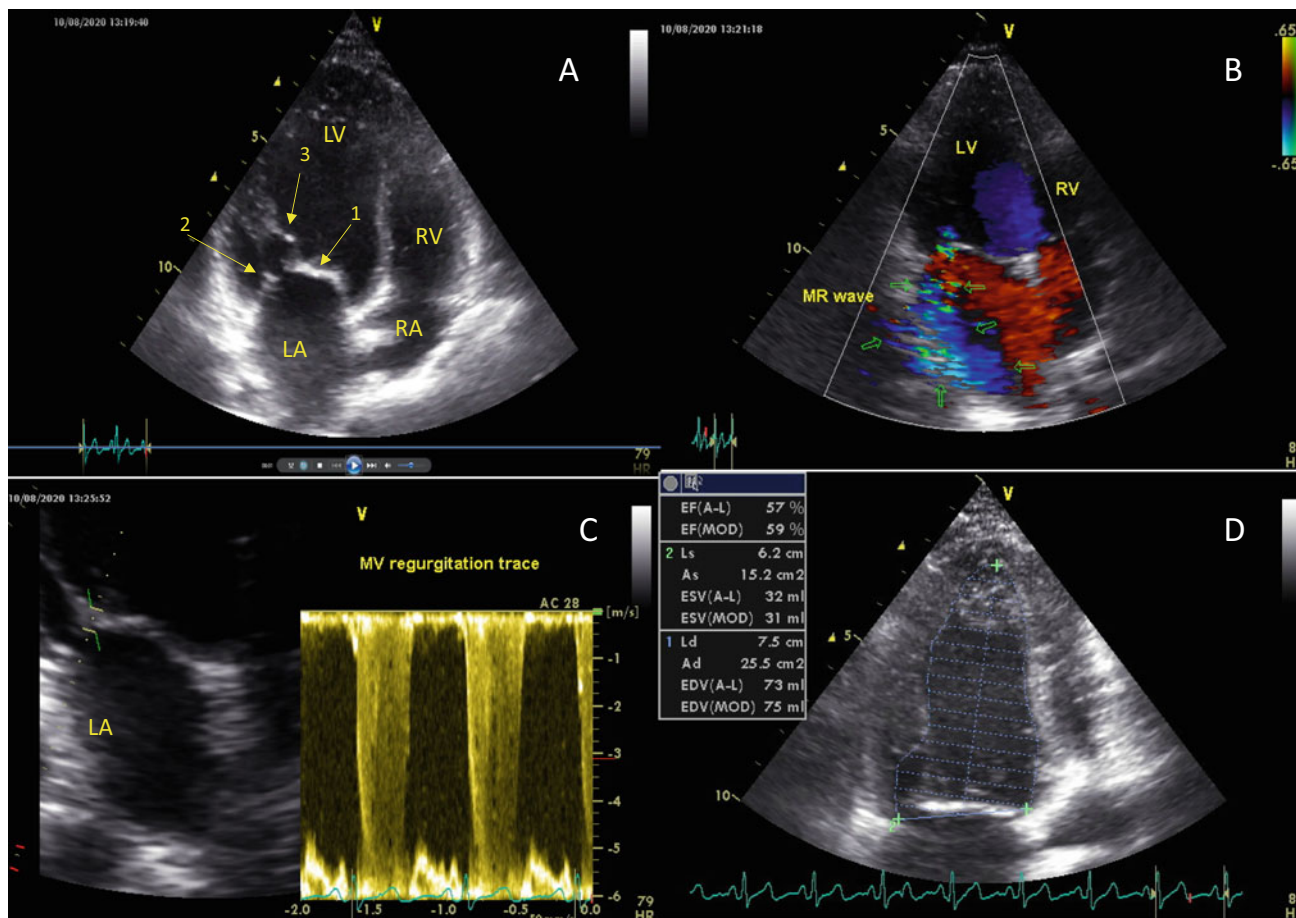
Echocardiography after recent coronary intervention in August 2020. a four-chamber view showing mitral valve with thickening of anterior cusp (arrow 1), shortening of posterior cusp (arrow 2), and calcifications in subvalvular apparatus (arrow 3). b Color Doppler showing mitral regurgitation grade III. The arrows surround
